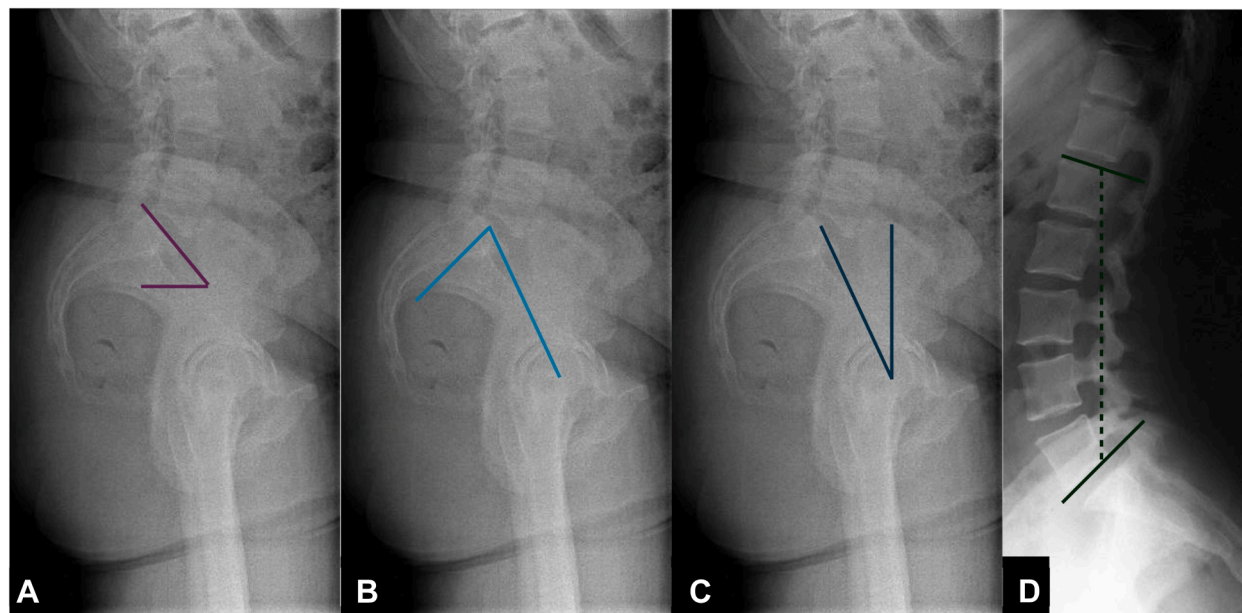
Measurements taken on lumbar lateral radiographs. (A) Sacral slope: angle subtended by a line tangent to the S1 superior endplate and a horizontal line. (B) Pelvic incidence: the angle between a line perpendicular to the S1 superior endplate midpoint and a line connecting the midpoint to the center of the femoral head. (C) Pelvic tilt: the angle between a line connecting the center of the femoral head to the midpoint of the S1 superior endplate and a vertical line from the center of the femoral head; also equal to 'pelvic incidence - sacral slope.' (D) Lumbar Lordosis: The angle between a line parallel to the superior endplate of L1 and the inferior endplate of L5.
